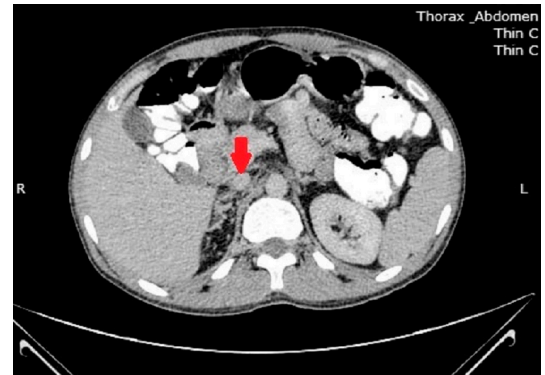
Postchemotherapy contrast-enhanced CT scan—complete resolution of inferior vena cava tumour thrombosis (arrow) after four cycles of VIP.
